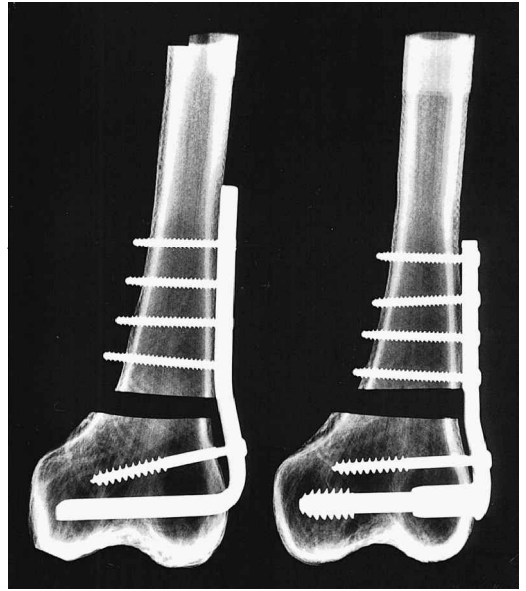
Radiograph of a Synthes dynamic condylar side plate and screw-femur construct and a 95° angled blade plate-femur construct.
